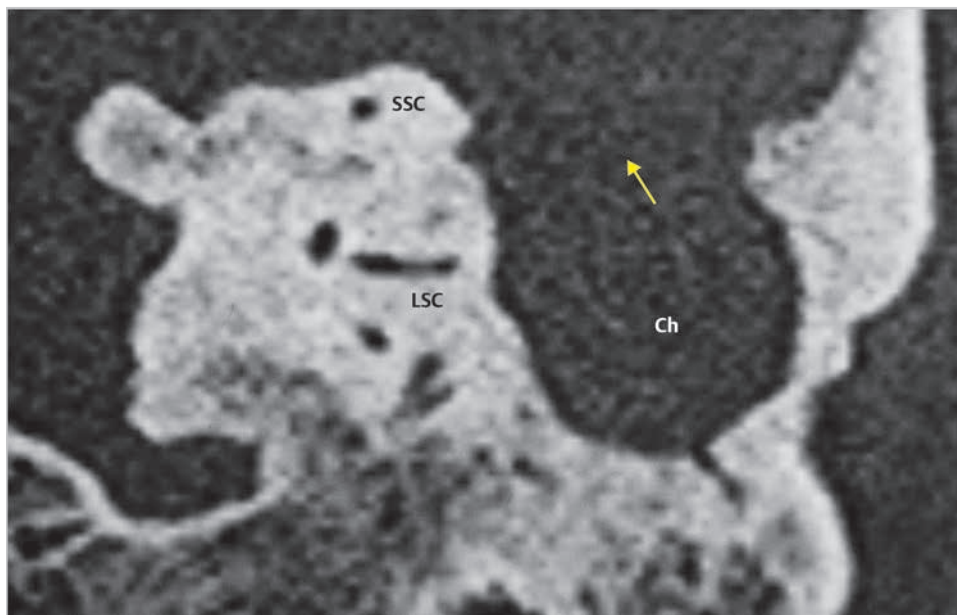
In coronal view, an extensive bony defect in the tegmen of the mastoid is demonstrated (arrow). The CT shows possible presence of meningoencephalic herniation in the mastoid. Ch, cholesteatoma; LSC, lateral semicircular canal; SSC, superior semicircular canal.
